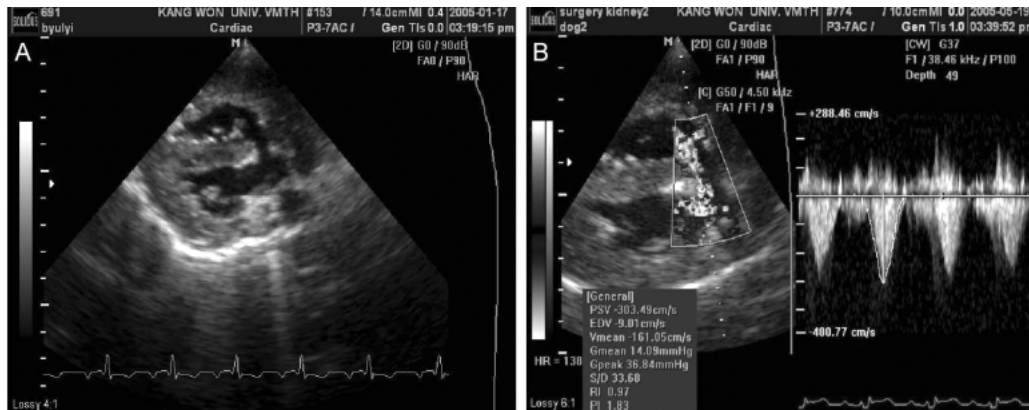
The 2-dimensional short-axis and colour flow Doppler echocardiogram at the papillary muscle from this case. A large septal defect lied in the left ventricular outflow tract just below the aortic valve (A). Doppler studies revealed the flow direction is right to left at 3.0 m/sec of peak velocity (pressure gradient; 36 mm Hg between two ventricles), and implied the septal defect is large (B).
